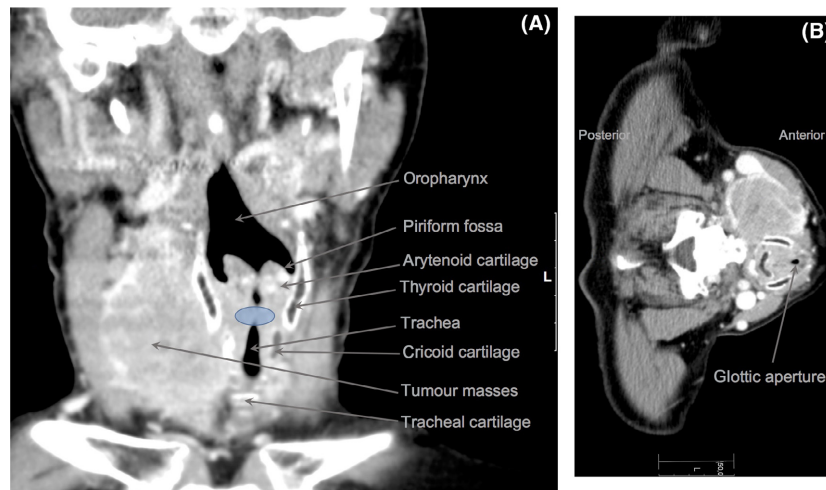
The CT scan demonstrates a dislocated larynx to the left due to bulky disease (A). (B) reveals a glottic aperture of 3×5 mm. Scale marking: (A) 10 mm per graduation mark; (B) 50 mm/10 mm per graduation mark, respectively. The blue ellipse in A shows the vocal cord plane.
